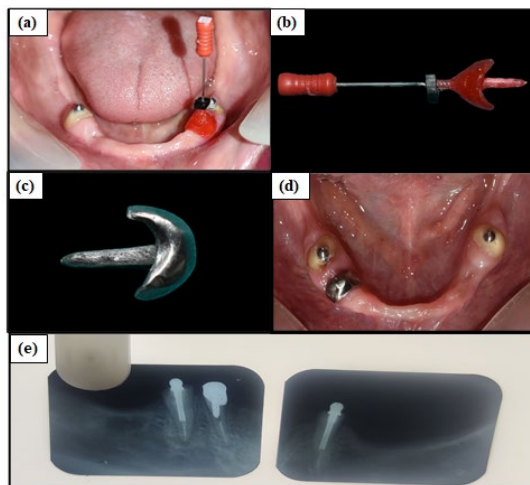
(a, b) Cementation of ball attachments and resin pattern preparation for coping on 44. (c) Processed coping (d) Cementation of coping and (e) Radiographic view after the cementation of attachments.
